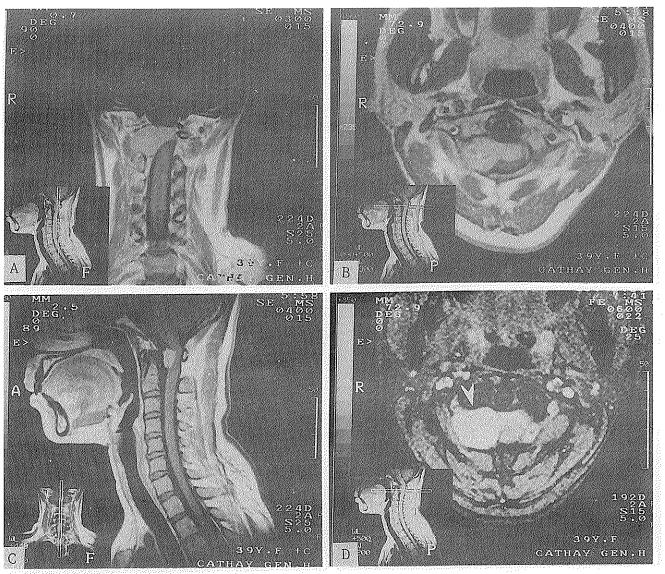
MRI coronal (A), axial (B), and sagittal (C) GD-T1W images revealing a nearly 3×2×2 cm dumb-bell extramedullary tumor crossed over the markedly dilated right C1-2 neuroforamen with compression over the cord ventrally. The tumor (arrowhead) is hyperintense on axial T2*W image (D).
